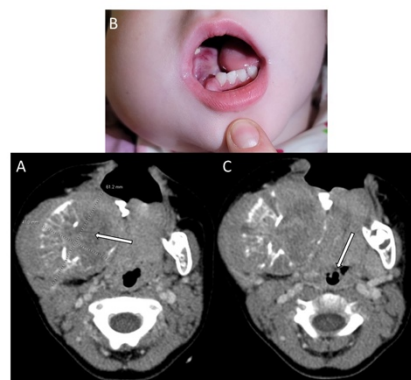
A: Computed Tomography (CT) scan of our patient's head and neck, with arrow pointing to right mandibular metastasis at widest diameter in the jaw; B: Comparative pre-intubation photo of our patient's right mandibular mass; C: Another slice of our patient's CT, showing midline shift but no tumor involvement of our patient's epiglottis.
